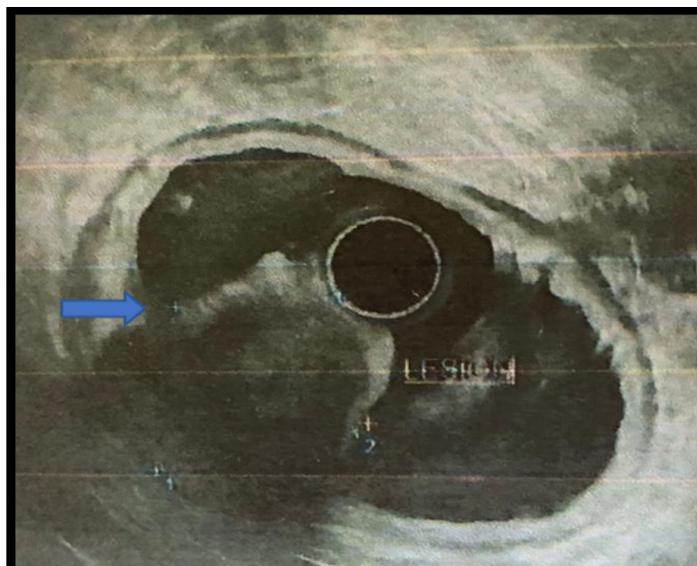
Subepithelial lesion in the antrum, seen on endoscopic ultrasound
